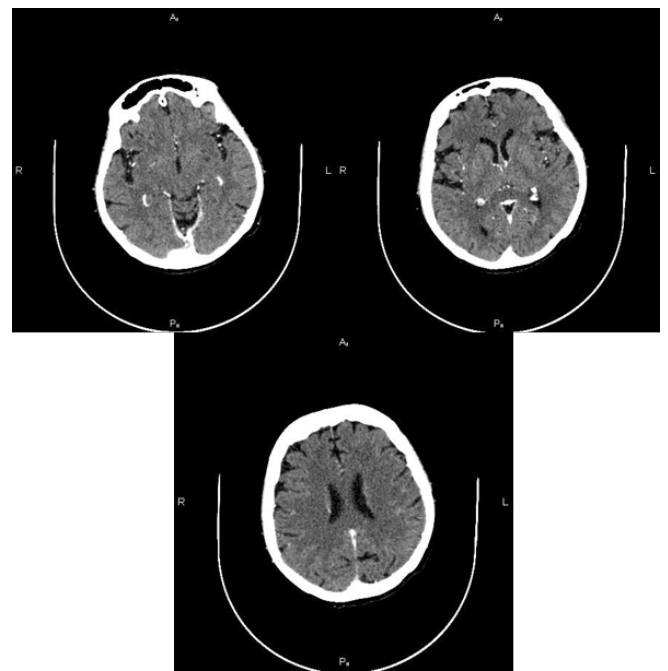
Cerebral computed tomography without evidence of focal lesions and no enhancement upon gadolinium administration.
